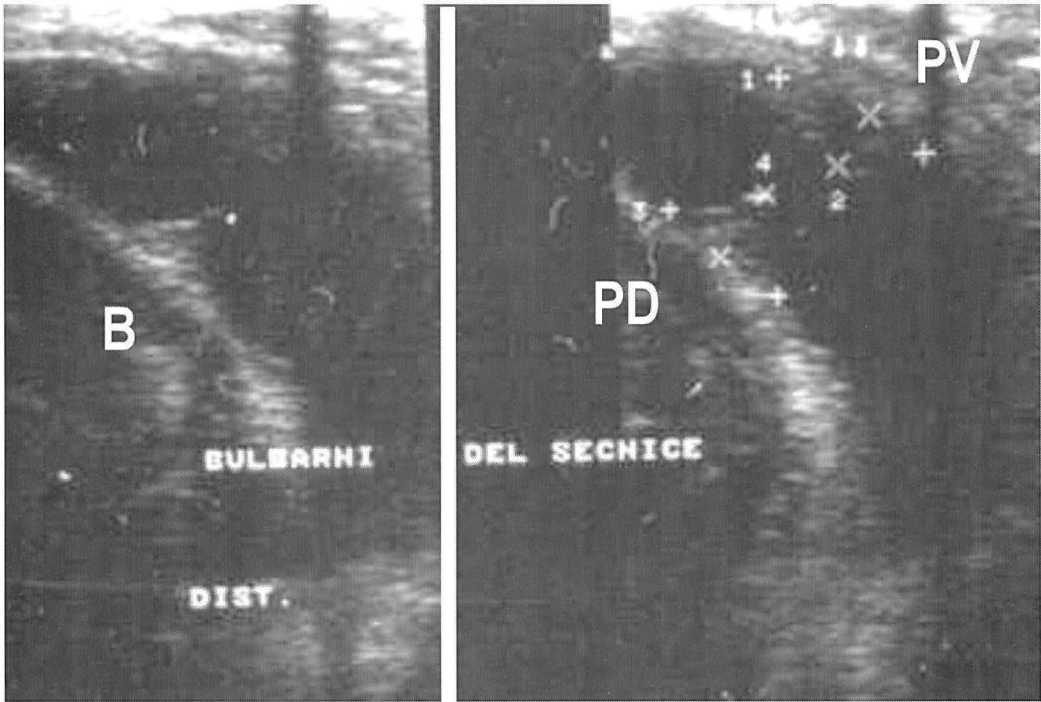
Sonographic urethrography-measurements of the periurethral changes ventrally (PV), and dorsally (PD).
